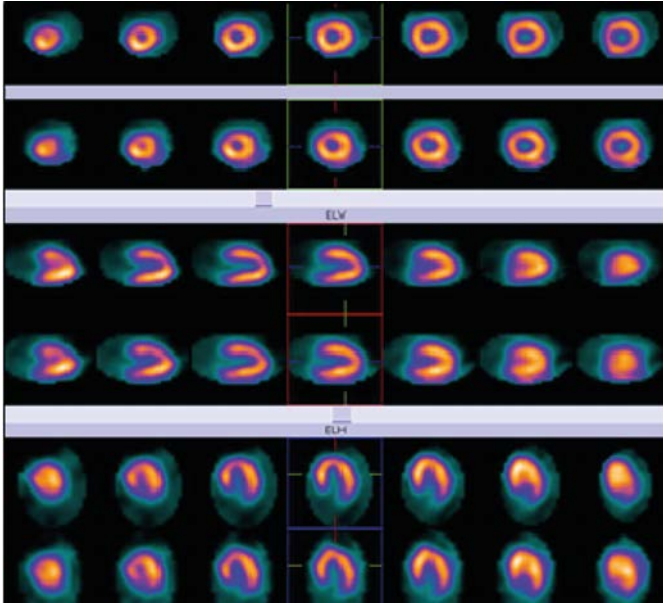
Stress (upper row on each set of paired images) and rest (bottom row)  $^{99m}\text{Tc}$ -sestamibi SPECT images.
